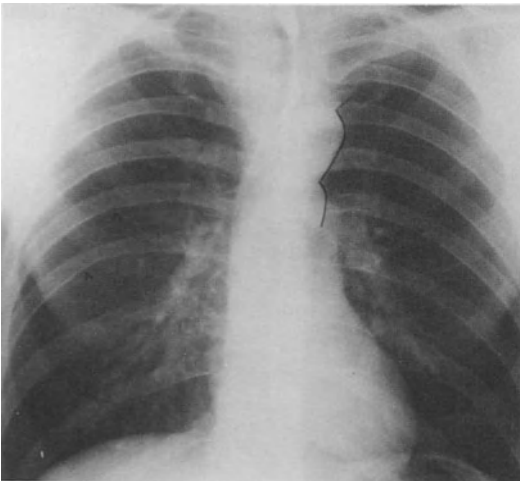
Chest X-ray in coarctation of the aorta demonstrating the “arabic 3” appearance produced by dilatation of the aorta proximal and distal to the coarcted segment. The left subclavian artery is also dilated. Rib notching is indicated by the arrows.
